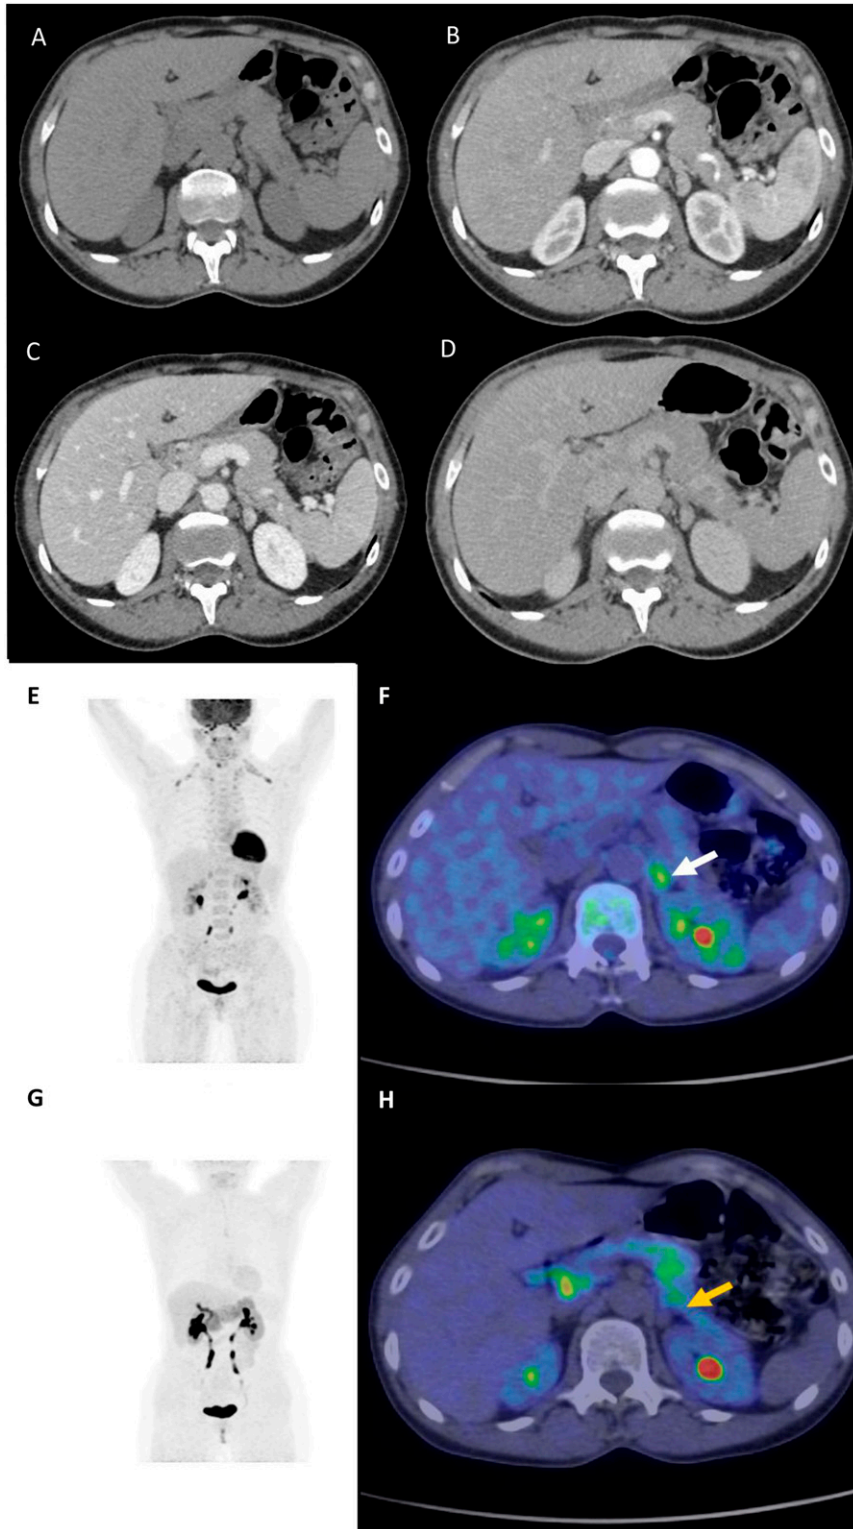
Radiological and nuclear imaging. (A–D) CT scan. Lesion of the medial limb of the left adrenal gland (dimension 13×14 mm). The region of interest for the assessment of the density was placed over two-thirds of the surface area of the mass in the axial view. The attenuation value assessment shows a density of (A) 32 HU on unenhanced CT, (C) 157 HU in the venous phase (at 70 to 80 seconds), and (D) 93 HU in the delayed phase (at 15 minutes) with absolute wash-out of 51% and relative wash-out of 40%. (E and F) ^{18}F -Fludeoxyglucose (^{18}F -FDG) PET scan: diffuse hyperfixation of both adrenal glands, with a
